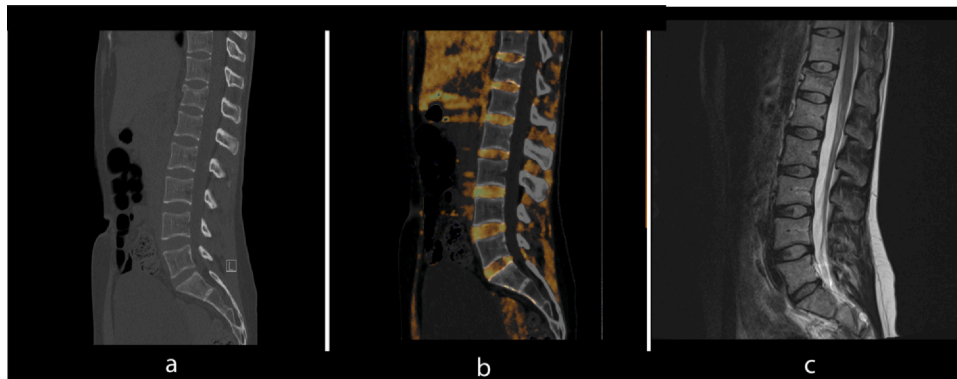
Sagittal reconstructions of gray-scale CT (a), collagen maps (b) and T2-weighted MRI (c) of the lumbar spine. This 32-year-old female patient has been referred to the emergency department with lumbar back pain after a car accident. The subsequent performed DECT revealed a compression fracture of TH12. Subsequently, a lumbar spine MRI was performed to rule out diskoligamentous injuries and further fractures. Sagittal reconstructions of DECT-derived collagen maps (b) visualize the collagen content of the lumbar disks, with higher signal in the annulus pulposus when compared to the nucleus pulposus.
